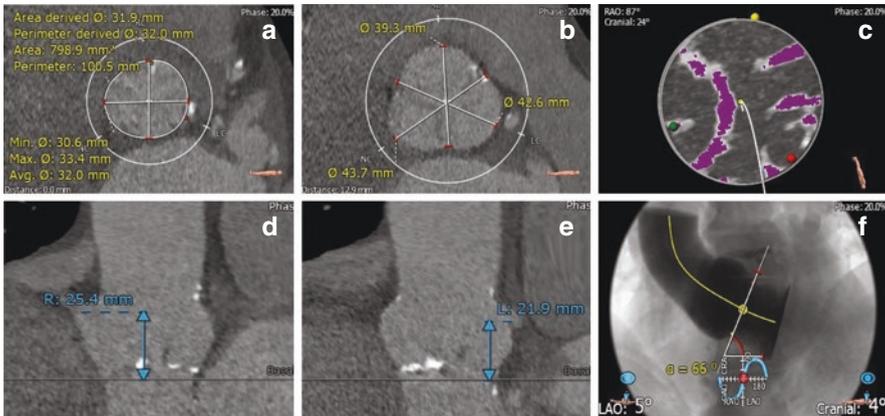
Cardiac CT analysis. (a) Aortic annulus area and diameters; (b) sinus of Valsalva diameters; (c) aortic valve calcium; (d) right coronary height; (e) left coronary height; (f) aorto-ventricular angle
